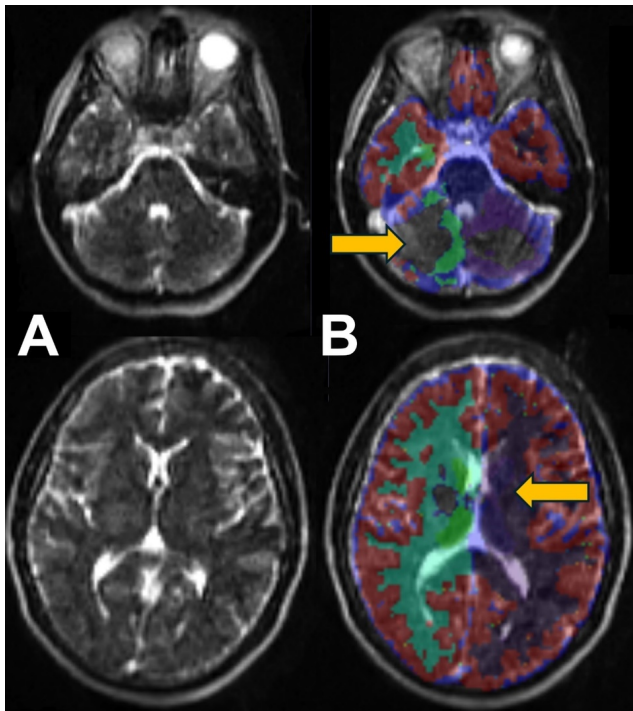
Segmentation quality of T2-weighted 64 mT scan acquired with scanner software version 8.8.1.
